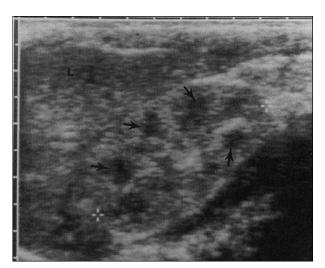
Ultrasonography showing that normal medullary pyramids in neonates are hypoechoic (arrows) when compared with the renal cortex. From Shackelford GD, Kees-folts D, Cole BR. Imaging the urinary tract. *Clin Perinatol.* 1992;19: 85–119. Reprinted with permission from Saunders, Inc.
